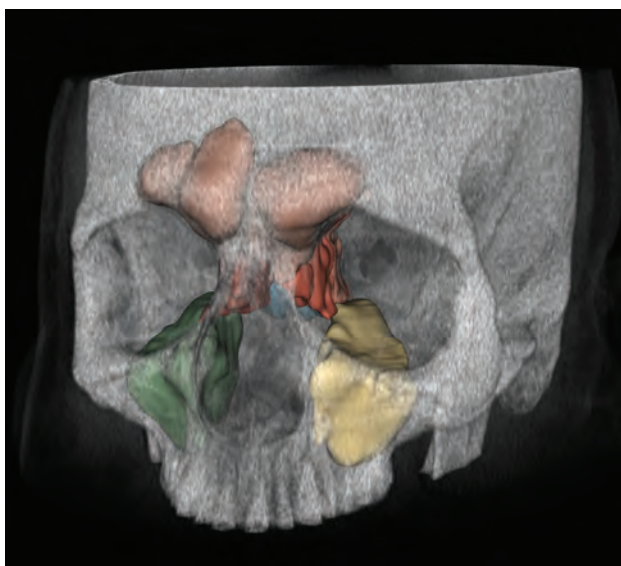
3D reconstructed sinus CT scan with bony overlay (gray) and segmentation of the paranasal sinuses (colored) produced by the algorithm.
